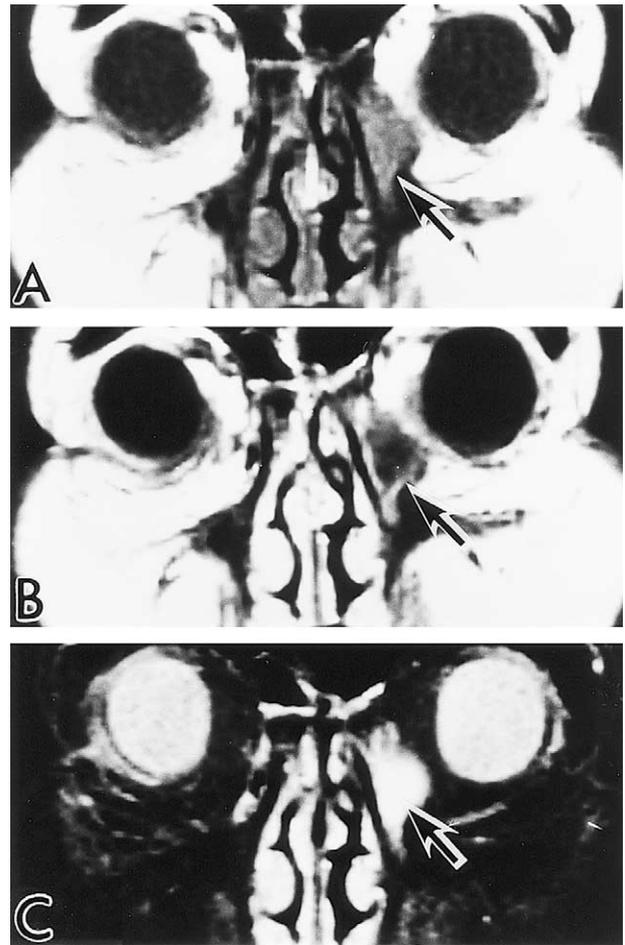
Magnetic resonance imaging coronal sections of a patient (case 6) treated by standard external dacryocystorhinostomy. (A) T₁-weighted (TW₁) image shows left intralacrimal sac space to be heterogeneous with slightly hyperintense and hypointense signals (arrow). (B) T₁W image after administration of gadolinium-diethylenetriamine pentaacetic acid exhibits the left lacrimal sac wall with increased contrast between the interior and the wall (arrow). (C) T₂-weighted image shows the lacrimal sac interior to be homogeneously hyperintense (arrow).
